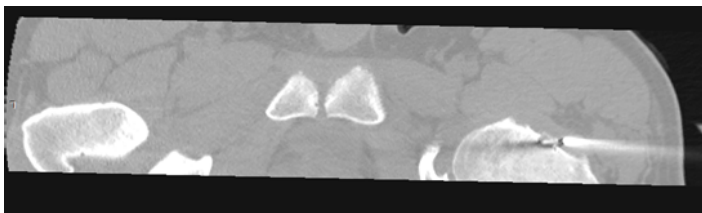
Radiofrequency ablation (RFA) under CT guidance of the osteoma osteoide lesion.
